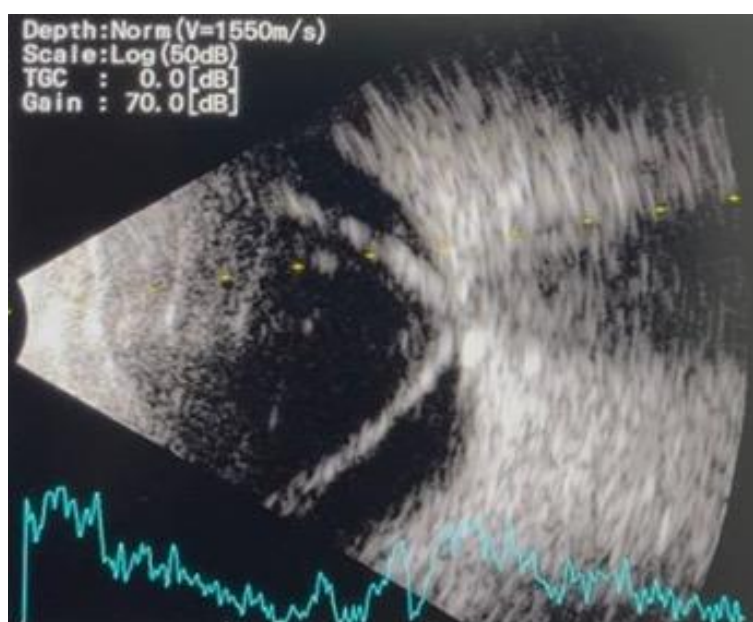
B-scan ultrasonography of the right eye demonstrating a highly reflective V-shaped membrane inserting at the optic nerve head and extending anteriorly, consistent with total retinal detachment. No intraocular mass, choroidal thickening or scleral nodule was identified. Acquisition settings are displayed in the upper left corner of the image, which is reproduced at the native resolution of the instrument printout.
